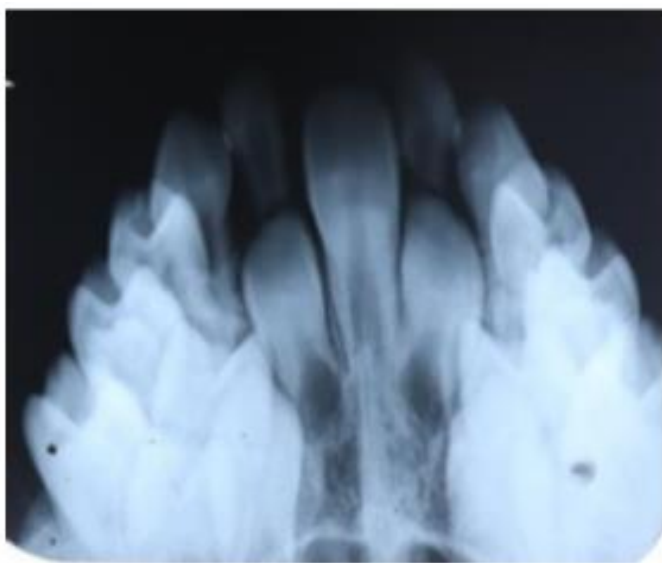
Occlusal radiograph showing presence of solitary central incisors present in midline
